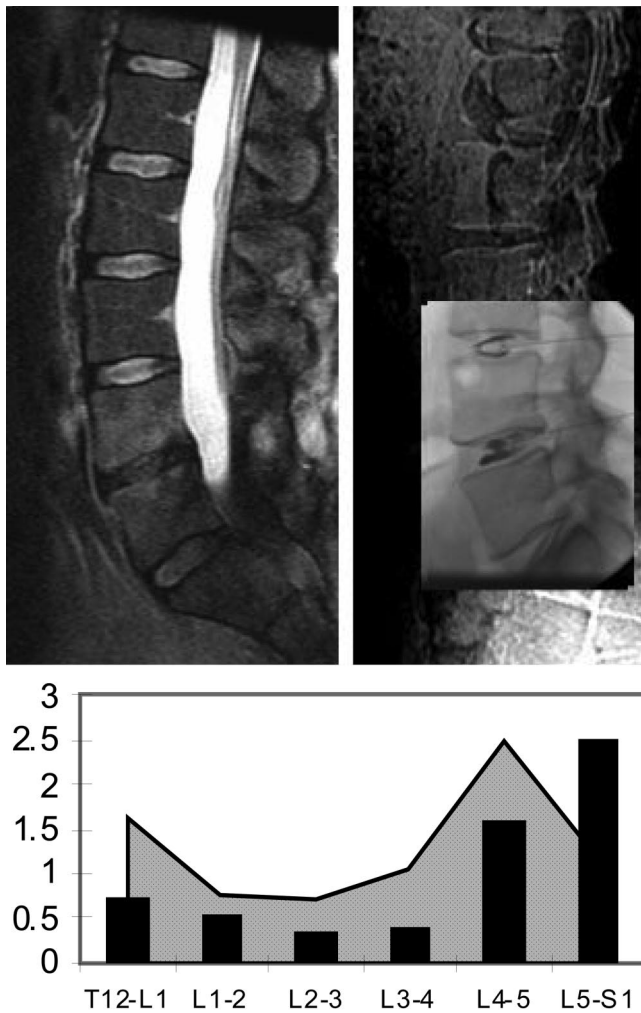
Magnetic resonance image (upper left), radiograph from discogram (upper right) in a patient with back pain. In the graph (bottom), the axial rotations measured at each lumbar vertebra by means of dynamic CT are shown. In this patient, signal intensity was decreased in the L4–L5 and L5–S1 intervertebral discs. At discography, concordant pain was found at L5–S1. Subsequently, a spinal fusion was performed at L5–S1 with a good result. The amount of rotation at each level that occurred with a 16° rotation of the torso is indicated by the height of the bar in the graph. The 95% confidence limit for rotations at each spinal motion segment is shown by the shaded areas in the graph. The normal values are based on a small sample size. Note that the L5–S1 intervertebral disc had excessive motion compared to the motion of normal L5–S1 discs.
